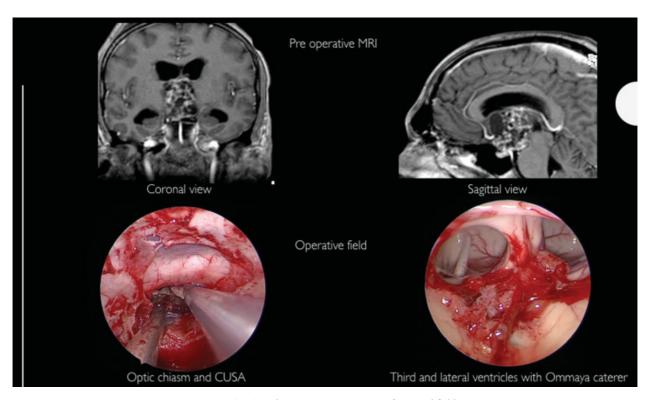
Preoperative magnetic resonance imaging (MRI) and intraoperative images of surgical field.
